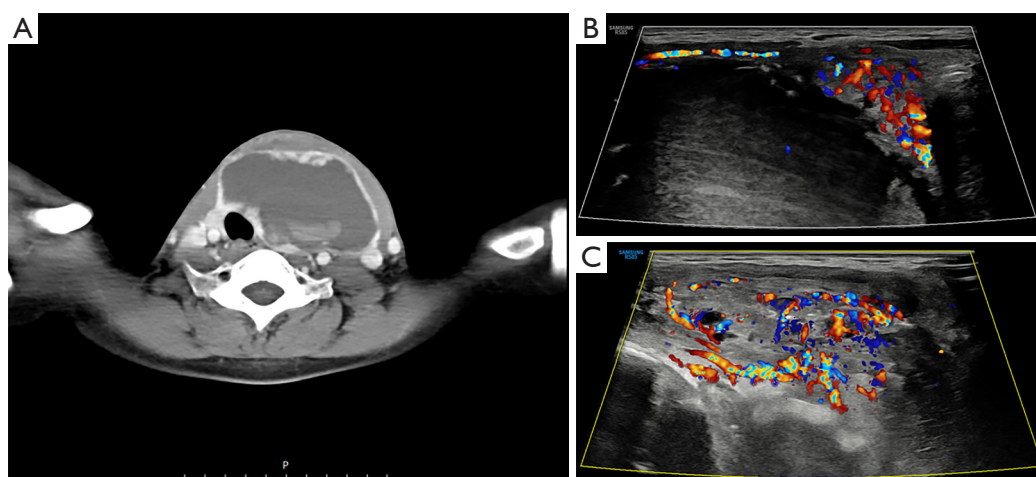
Radiologic findings on POD 14 and 28. (A) Axial CT scan of the neck (POD 14); (B) thyroid ultrasonography before radiofrequency ablation (POD 28); (C) thyroid ultrasonography after radiofrequency ablation and aspiration (POD 28). A hemorrhagic cyst was still observed in the CT scan on postoperative day 14 (A). Before (B) and after (C) radiofrequency ablation and aspiration, a highly vascular thick cystic wall was observed on ultrasonography. POD, postoperative day; CT, computed tomography.
